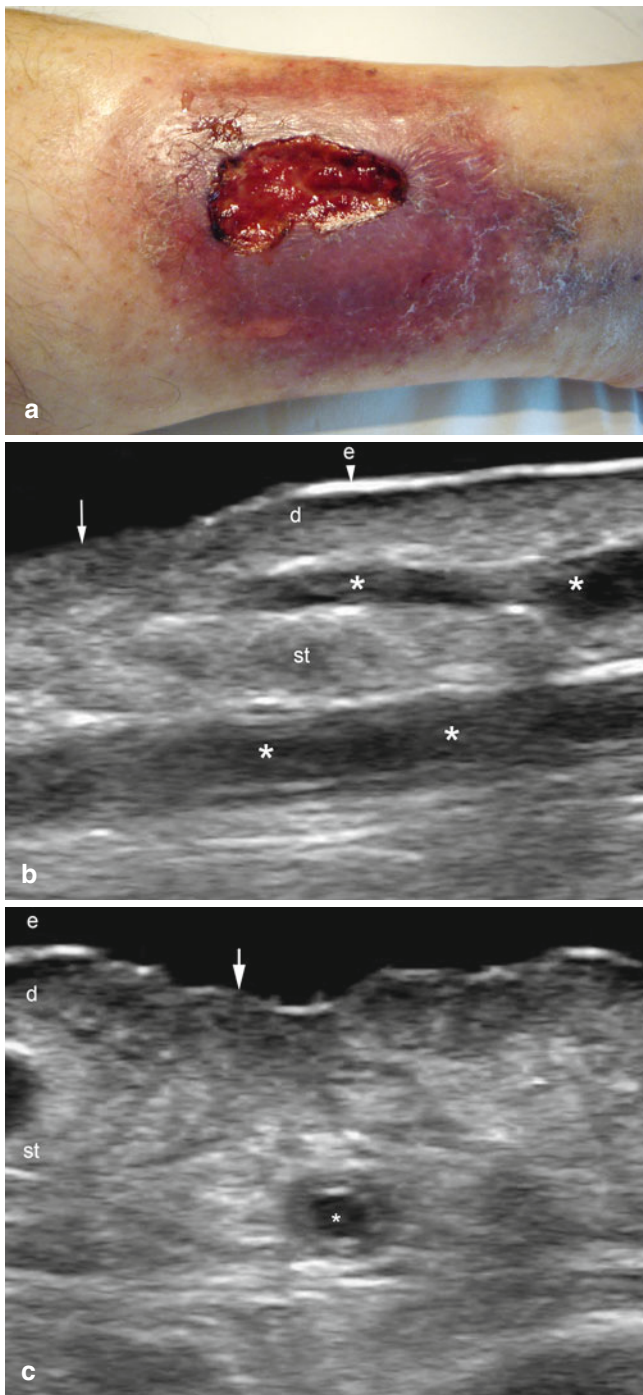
(a–c) Venous ulcer. (a) Clinical lesion. (b) Gray scale ultrasound image (longitudinal axis) at the border of the ulcer shows interruption of the epidermis (*arrow*) and dilated anechoic venous vessels (*) in the underlying subcutaneous tissue. Increased echogenicity of the subcutaneous fatty tissue is also detected. (c) Gray scale ultrasound image (transverse view) demonstrates increased thickness of the wall of a subcutaneous venous vessel (*) secondary to inflammation. The *arrow* is pointing out the disruption of the epidermal layer. *Abbreviations:* *e* epidermis (*arrowhead*), *d* dermis, *st* subcutaneous tissue
